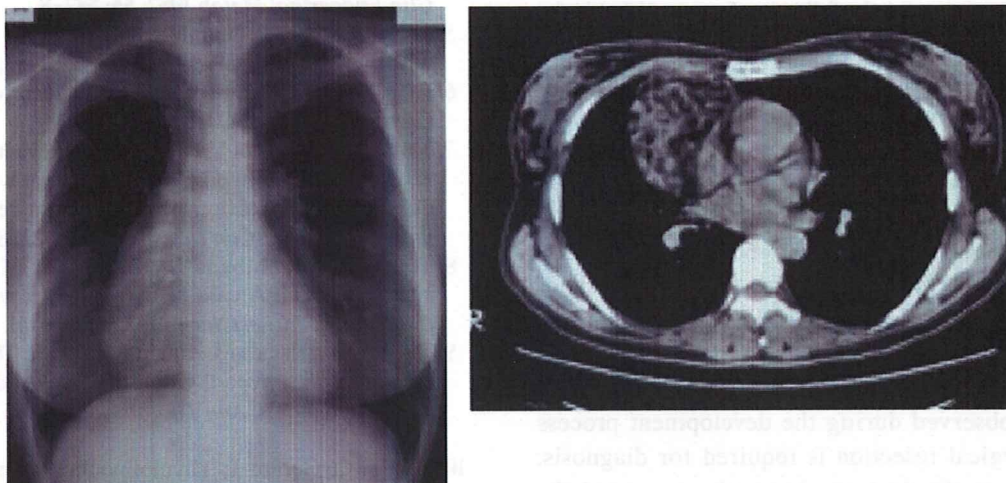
A chest radiograph (A) and CT scan (B) showing a significant decrease in the size of the mass. Involution of the soft tissue attenuation area is marked. As a result, the fatty tissue attenuation component is predominant.
